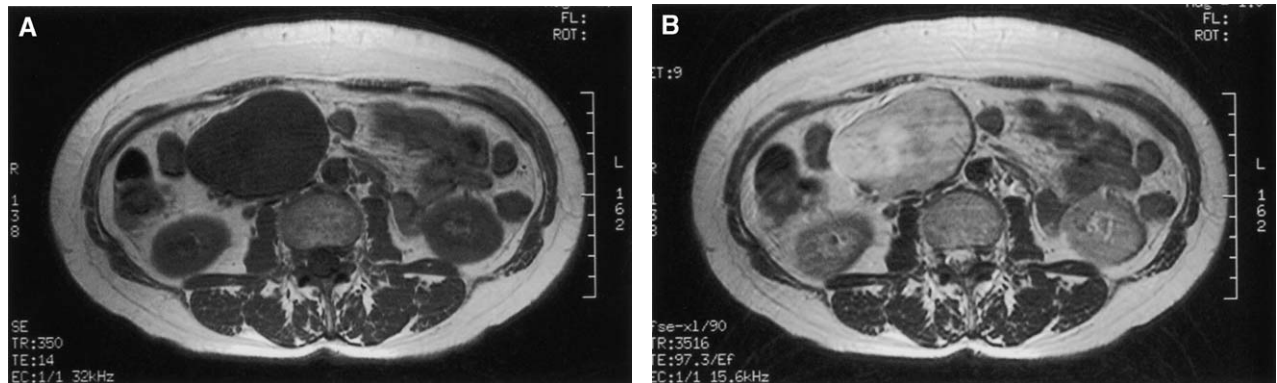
(A), T1-weighted MR image shows a round mass of homogeneous intermediate signal intensity similar to skeletal muscle in the right anterior mid abdomen. (B), T2-weighted MR image shows an increased signal intensity in the mass.
